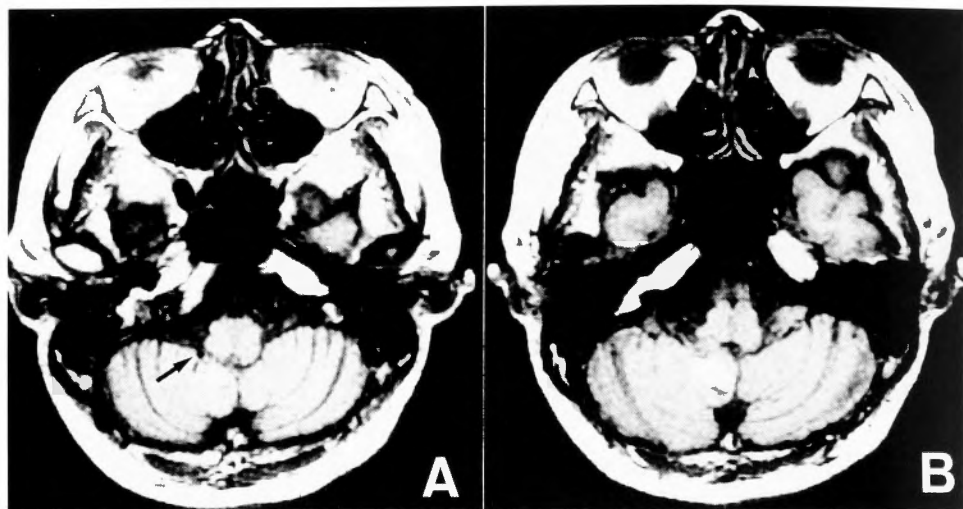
T-1 weighted MR images (A,B) demonstrate a hematoma in the right cerebellar tonsil and an aneurysm on the ventral surface of the tonsil, laterally to the inferior cerebellar peduncle (arrow).
